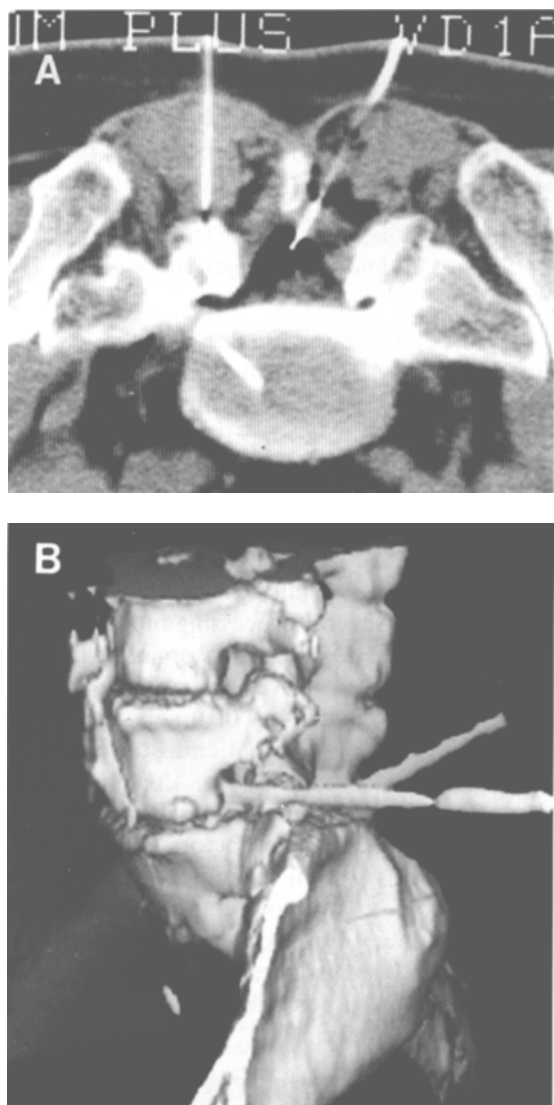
CT-scopically intraspinal control of microinstruments. (A) The tip of the cannula is placed under CT-scopy close to a herniated intervertebral disk. Microendoscopes, laser fibers, or microforceps are then inserted through this cannula. A further instrument is inserted into the intervertebral disk for laser nucleotomy. Another cannula is placed for local anesthesia of the small facet joints. (B) 3 D reconstruction of the spine with instruments. (C) Endoscopic view inside the spinal canal onto the herniation.
